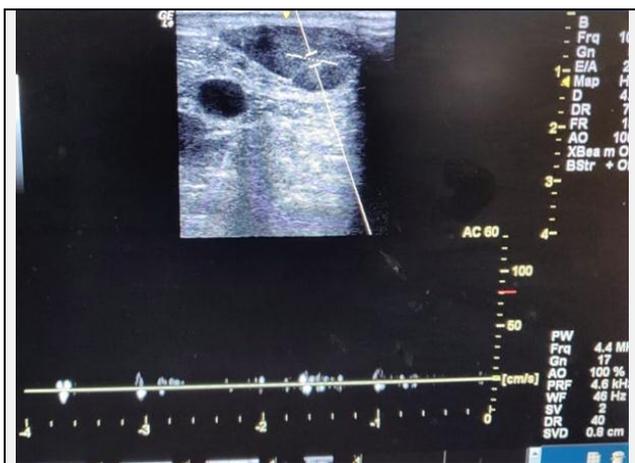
Ultrasonographic Finding of Pseudoaneurysm
